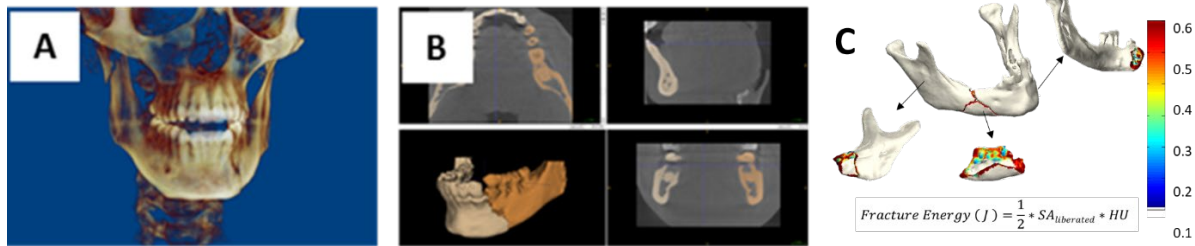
Pre-operative CBCT 3D image (A), Segmentation (B), Computed fracture energy (C).
